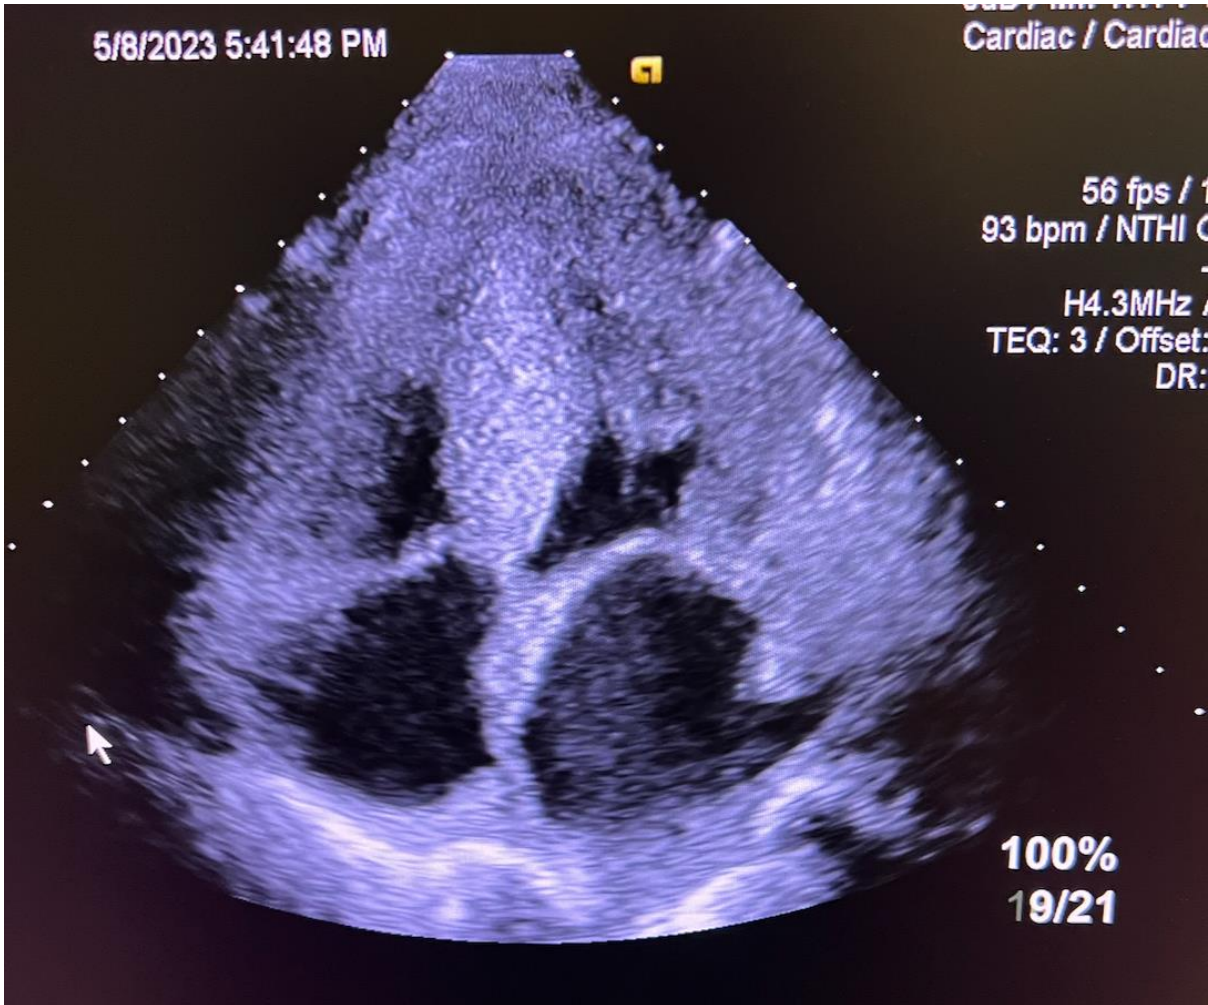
Patient transthoracic echo showing evidence starry sky appearance which suggestive of cardiac amyloidosis.
